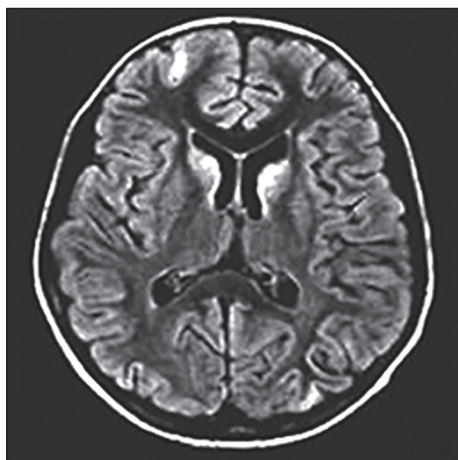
T2 weight fluid attenuated inversion recovery magnetic resonance imaging (MRI) of a 13-year-old girl who had history of high-grade fever, headache and loss of consciousness 2 years back and later developed generalized dystonia. MRI shows hyperintensities in bilateral caudate, left posterior parietal and right frontal grey matter
